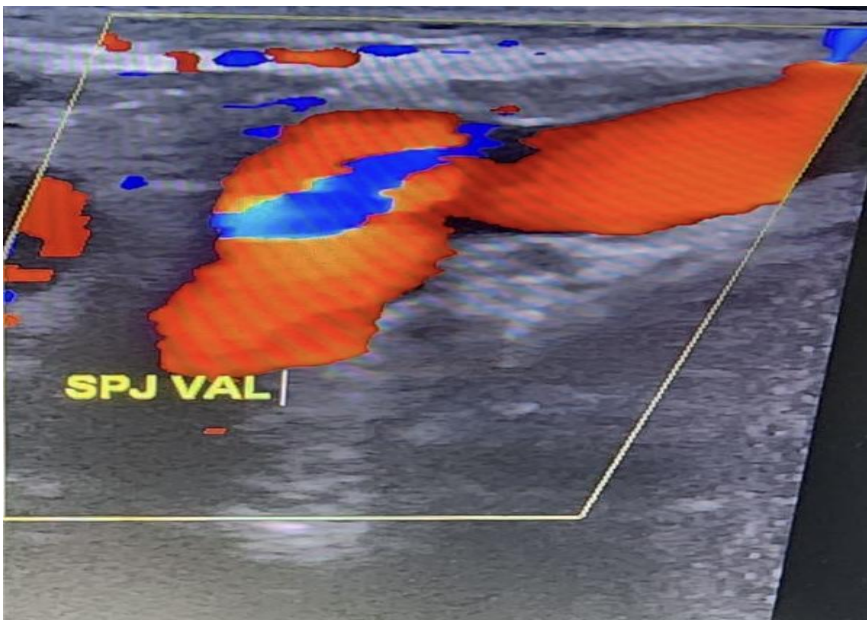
(A): Color doppler ultrasound showing persistent flow at the saphenopopliteal junction (SPJ) during Valsalva maneuver.
